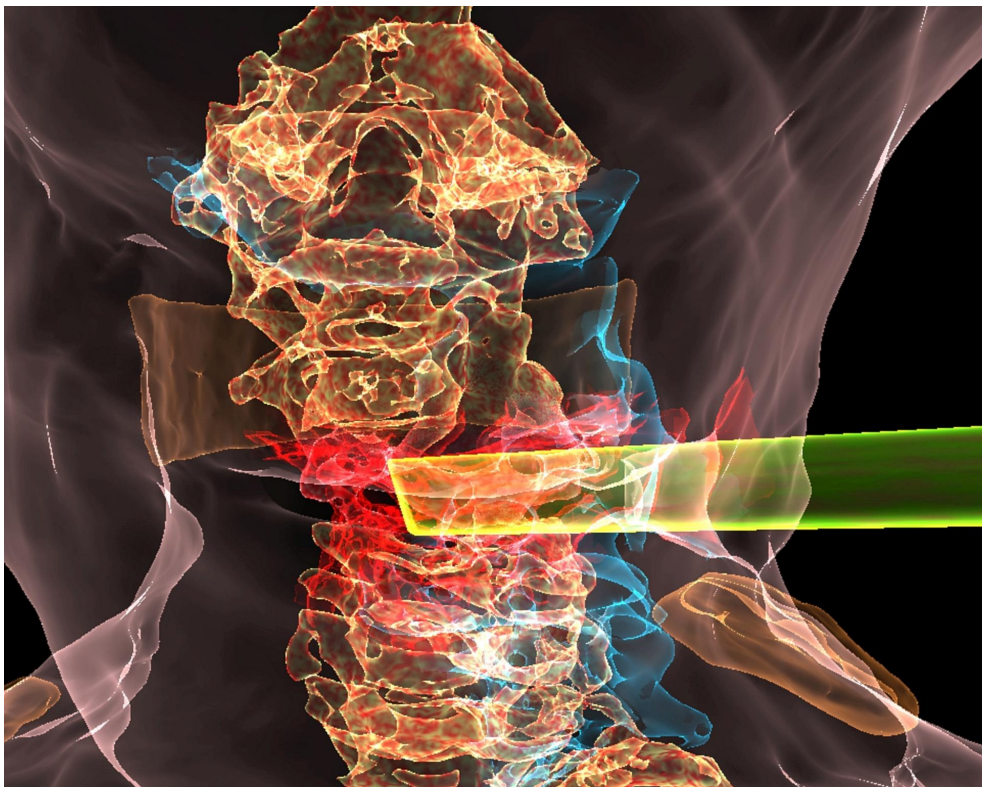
3D CT frontal view showing proposed trajectory of penetrating object (*in green*), tissue tract (*in red*), associated hematoma (*in blue*) and cervical spine (*in orange*).
